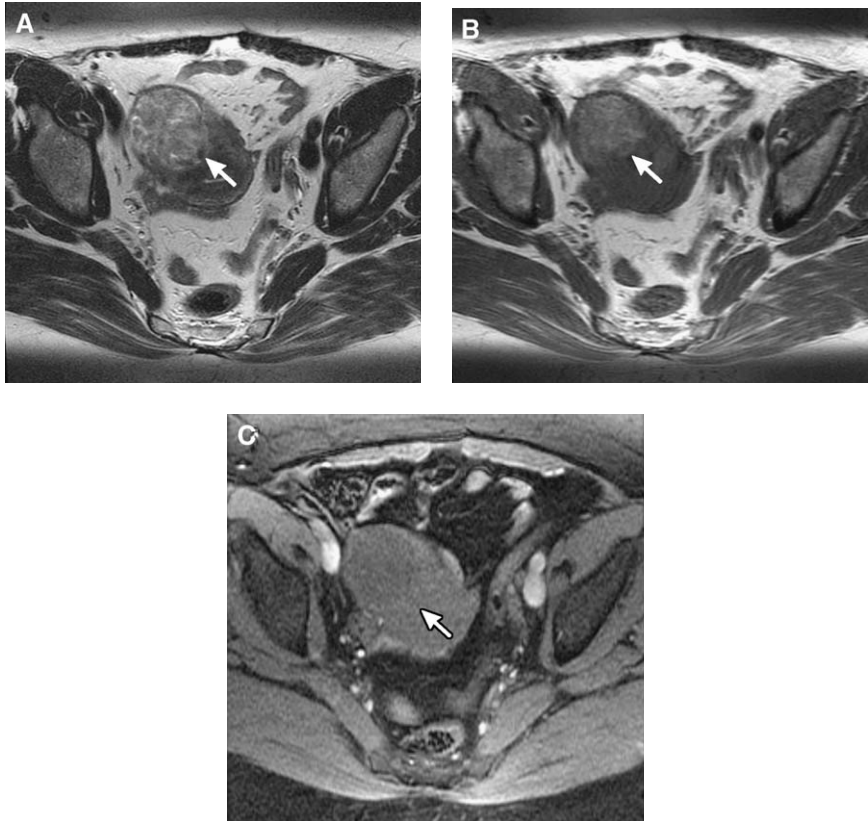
(A) Axial T2-weighted scan exhibits a subserosal myoma (arrow) that has internal signal that is isointense with fat. (B) Axial T1-weighted image also shows internal signal that is isointense with fat (arrow). (C) Fat-suppressed sequence proves that high signal is fat because it suppresses (arrow) and, therefore, the mass is a lipoleiomyoma.
